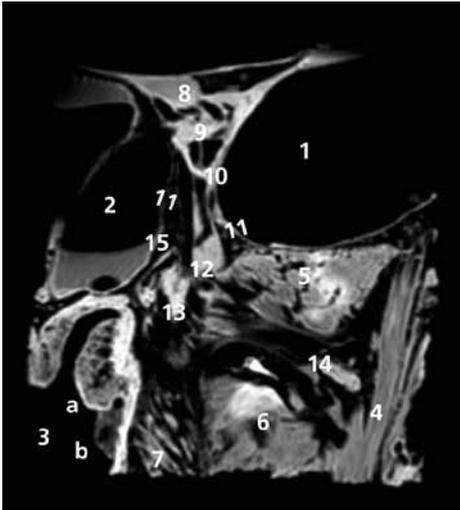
Coronal MR image of left PPF
